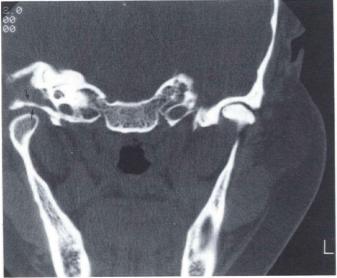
Pre HBO therapy: high-resolution CT of the right temporal bone (coronal view). Erosion of anterior bony wall of external auditory canal. Opacification of the mastoid cavity.
